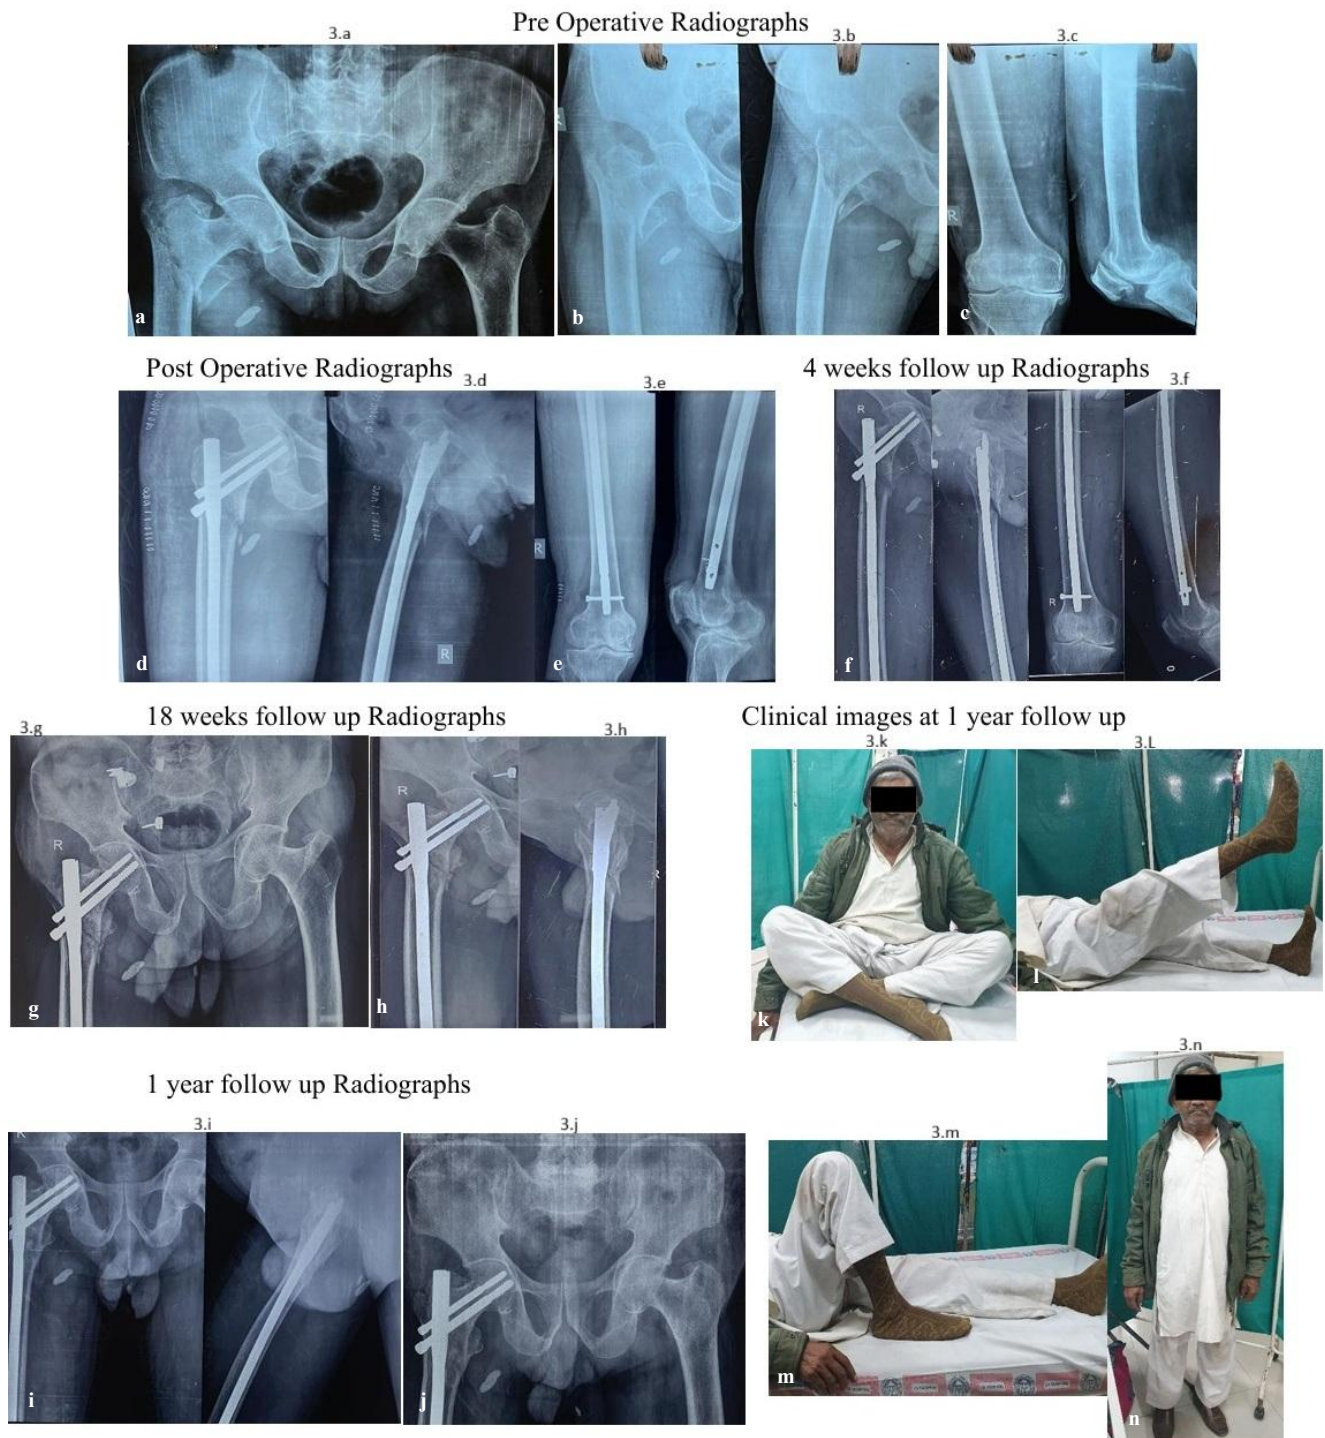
(a-n): Case 3, (a-c): Pre-operative X-ray, (d and e): immediate post-operative X-ray, (f-j): follow-up X-ray showing union, (k-n): clinical images at 1 year.
